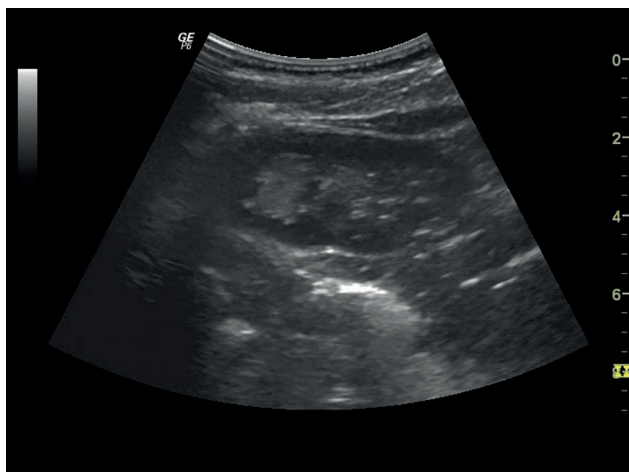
Presence of ultrasound contrast media in dilated pyelocaliceal system of the kidney is suggestive of VUR
